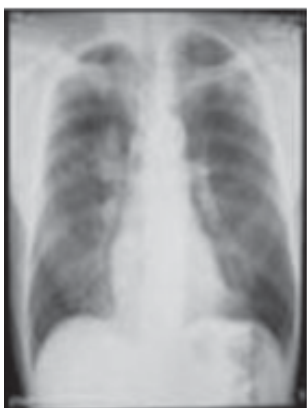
PA chest X-ray at the first day of hospitalization.
